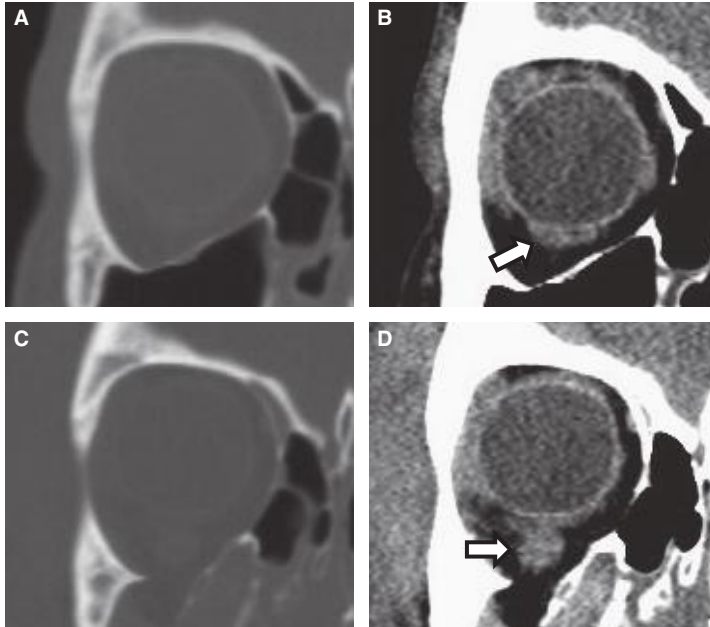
A, Coronal CT image showing normal inferior rectus anatomy in a bone window, and B, in a soft tissue window. The inferior rectus muscle (*arrow*) appears flattened in its correct position. This indicates that the fascial sling of the globe remains intact. The extraocular muscles are best appreciated by viewing the CT scan in a soft tissue window such as a brain window (which is shown in A). C, Coronal CT image showing orbital floor fracture with inferior rectus entrapment in a bone window, and D, in a soft tissue window. The inferior rectus (*arrow*) appears round and inferiorly displaced. This indicates disruption of the fascial sling of the globe. The rectus muscle and periorbita have prolapsed into the defect of the orbital floor fracture.
